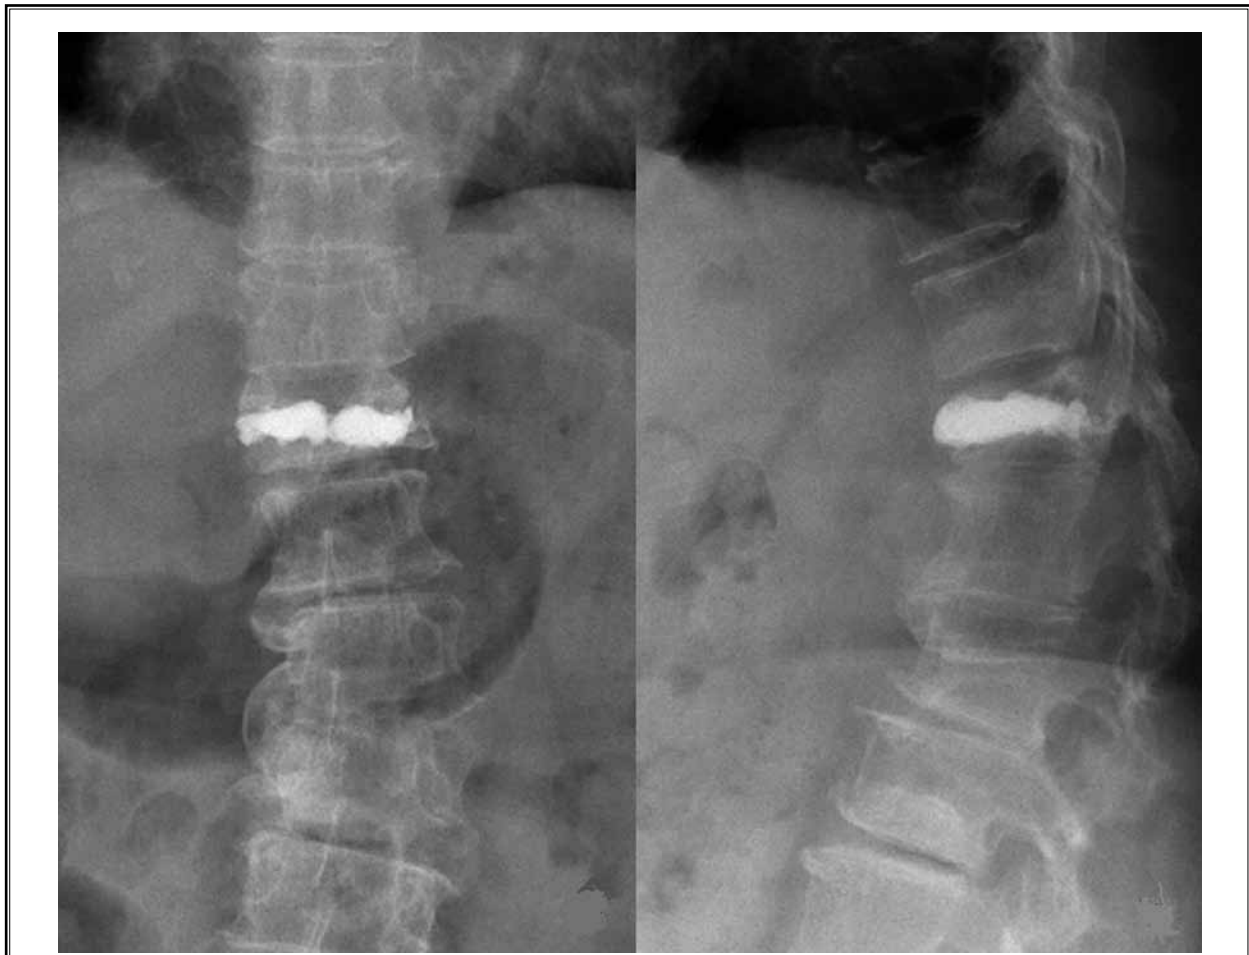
X-ray films showed no significant loss of correction of vertebral height or kyphosis after 16 months of follow-up.
